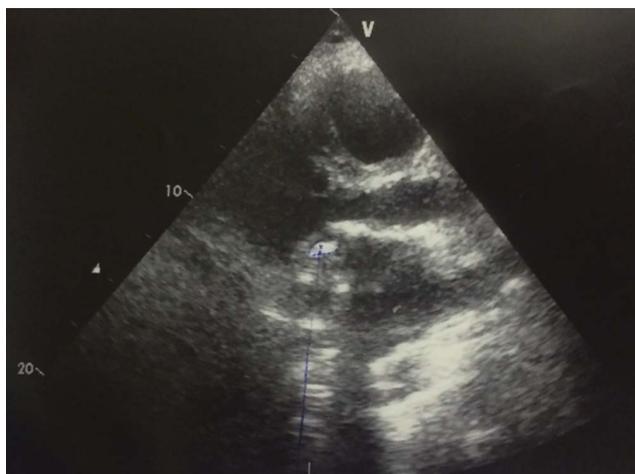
Transthoracic echocardiogram of patient C.: a floating vegetation (0.9×1.2 cm) on a prosthetic mitral valve
